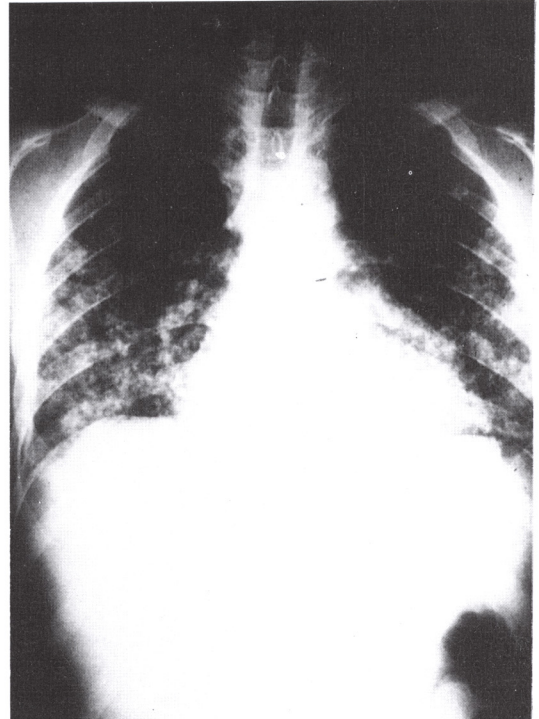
Plain X-ray film of the chest in case 3 showed diffuse interstitial infiltration over the whole lung fields.
